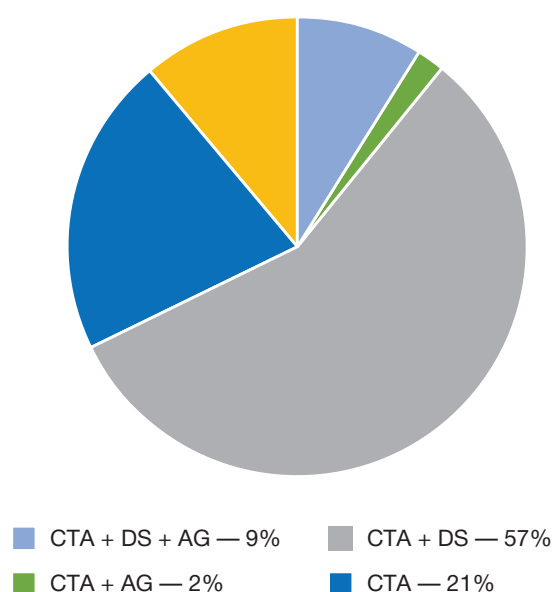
The structure of pre-operational examination in patients with hemodynamically significant stenosis of the carotid arteries. CTA — computed tomographic angiography; DS — duplex scanning of the brachiocephalic arteries; AG — transcatheter X-ray contrast angiography. [From the archive of the Federal State Budgetary Institution «Federal Scientific and Clinical Center» under the Russian Federal Medical-Biological Agency, 2025. Published for the first time].
